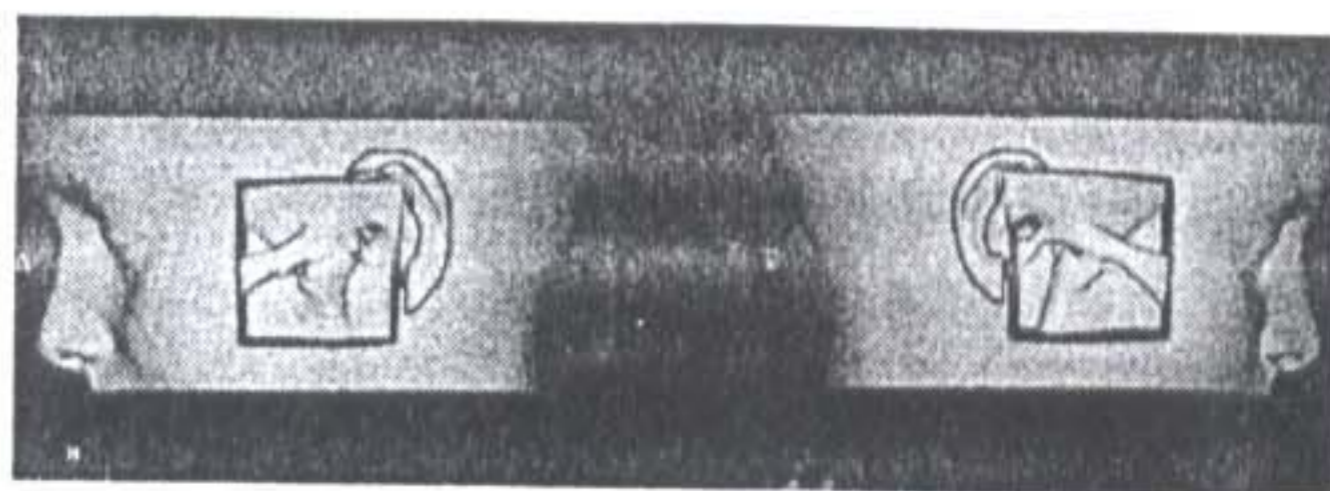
3-dimensional CT demonstrating bilateral ankylosis
